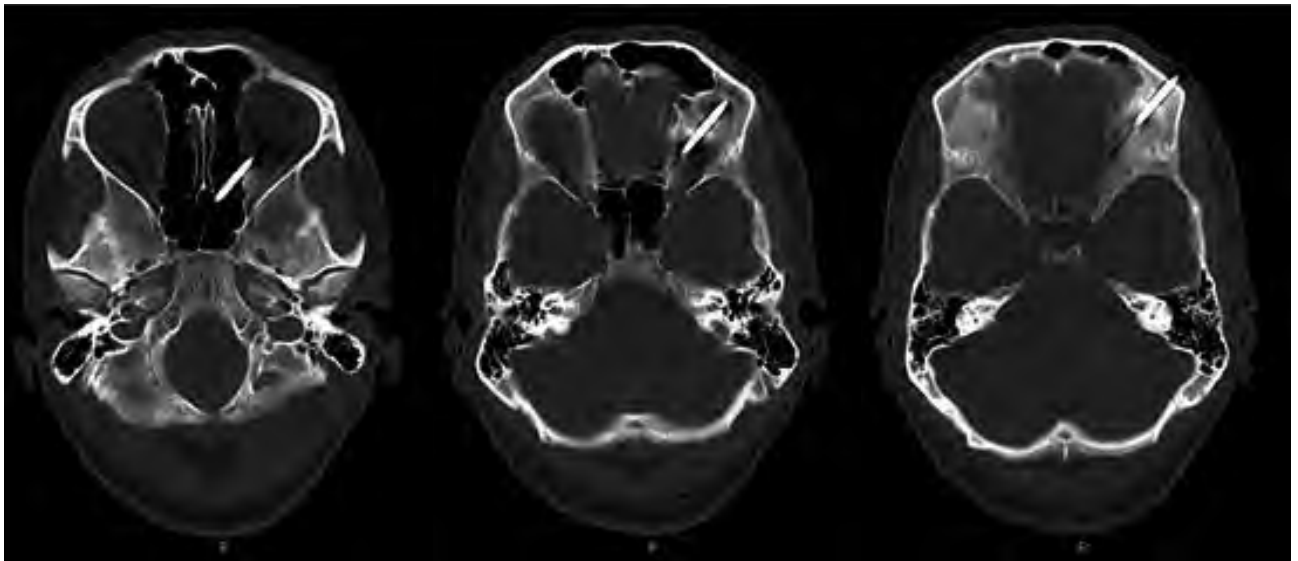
Sequential cranial CT slices showing the trajectory of the screwdriver shaft.
